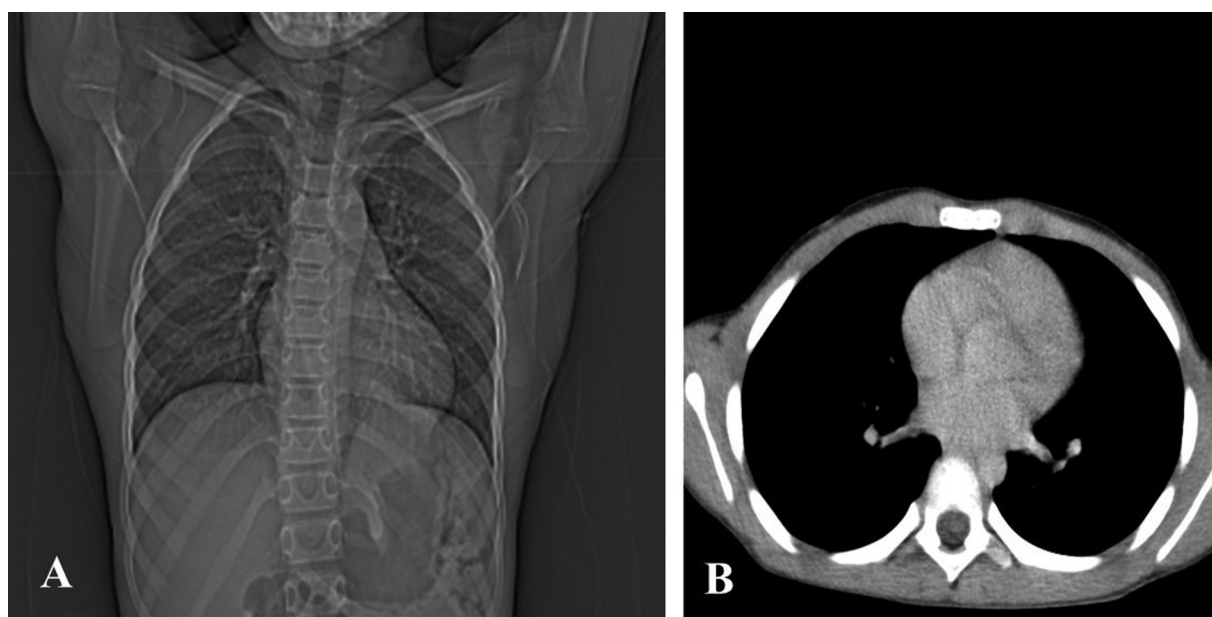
(A, B) Posttreatment follow-up chest high-resolution computed tomography images demonstrating a small area of atelectasis in the left lower lobe.
